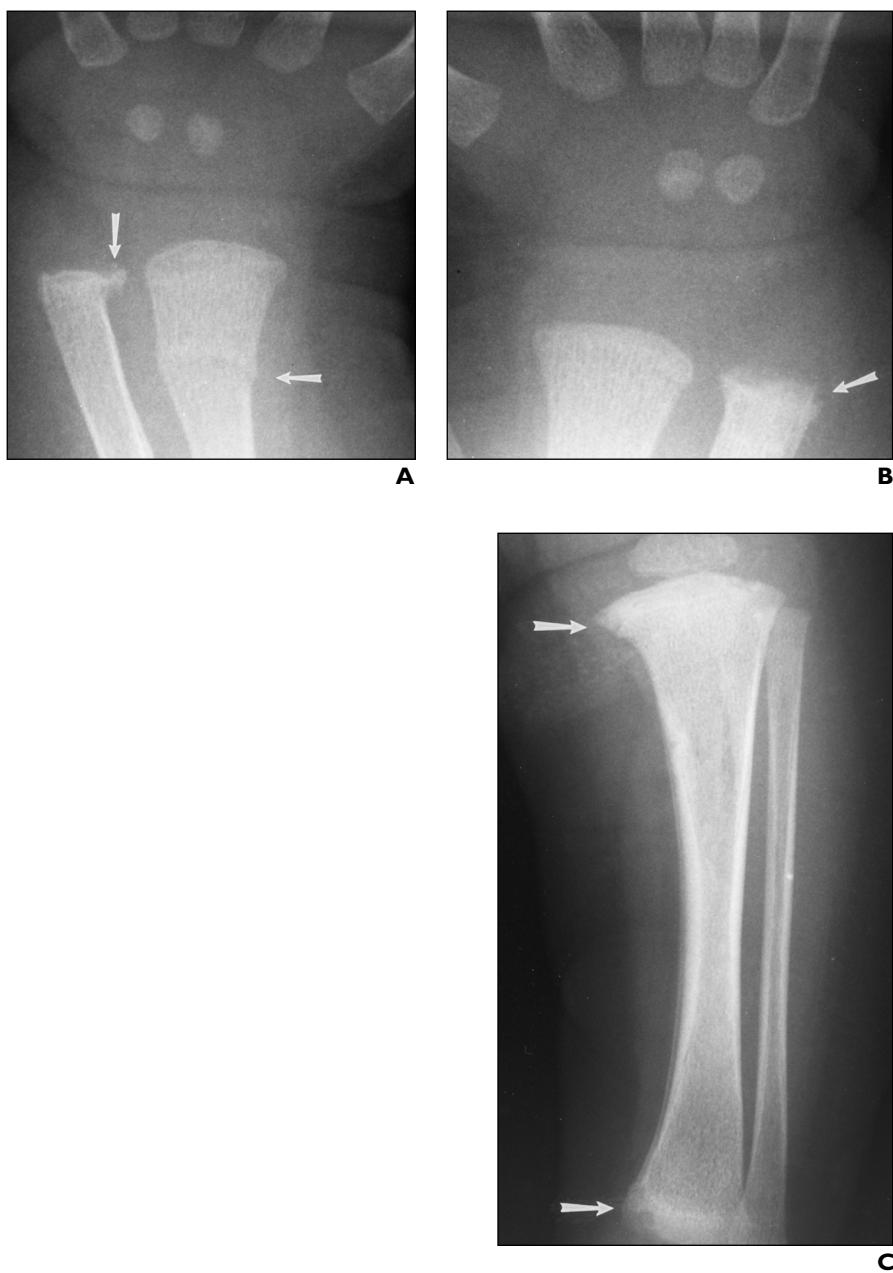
5-week-old female infant with multiple blunt force injuries of chest and abdomen and shaking injury of head (recent and remote subdural hemorrhage found at autopsy). These extremity fractures were detected on postmortem skeletal survey. Victim's father was convicted of murder and her mother was charged with neglect. A, Posteroanterior radiograph of left wrist reveals transverse fracture of distal left radial diaphysis and corner fracture of distal left ulnar metaphysis (arrows). B, Posteroanterior radiograph of right wrist shows classic metaphyseal fracture of distal right ulna (arrow). C, Anteroposterior radiograph of left tibia and fibula show classic metaphyseal fractures of proximal and distal left tibia (arrows).
